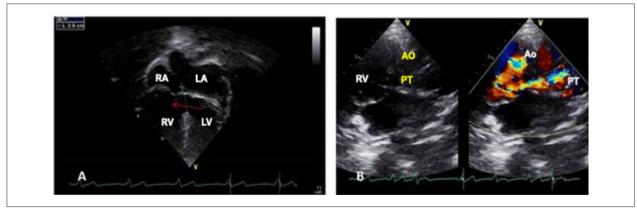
Echocardiogram shows in the 4-chamber view the large ventricular septal defect (arrow) in the inflow tract and in the subcostal view, the two large vessels emerging from the right ventricle, with the aorta to the right of the pulmonary artery. RA: right atrium; LA: left atrium; RV: right ventricle; LV: left ventricle; Ao: aorta; PT: pulmonary trunk.
